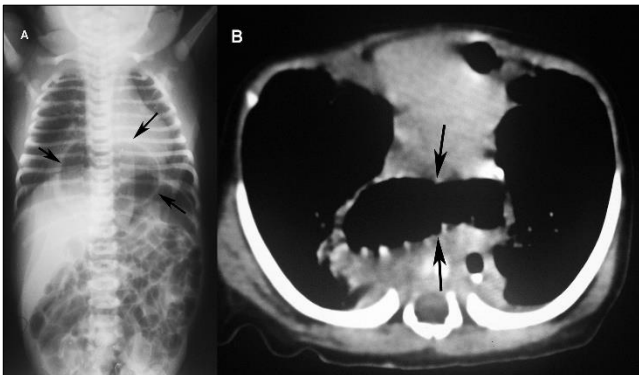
Plain radiograph (panel a) and computed tomogram (panel b) showing herniated stomach through the esophageal hiatus (arrows).
